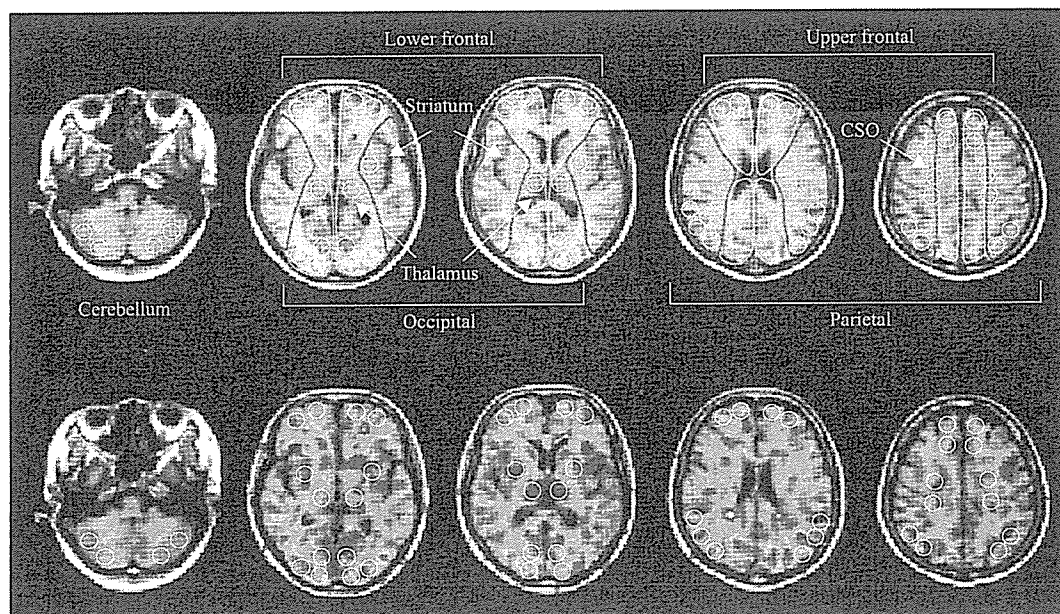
ROI setting. Multiple circular ROIs consisting of 96 pixels (1.58 cm<sup>2</sup>) were placed on the brain regions on the reformatted MR images (upper row) with the same pixel size as that of PET, which were automatically transferred onto the PET images (lower row). CSO, centrum semiovale.
